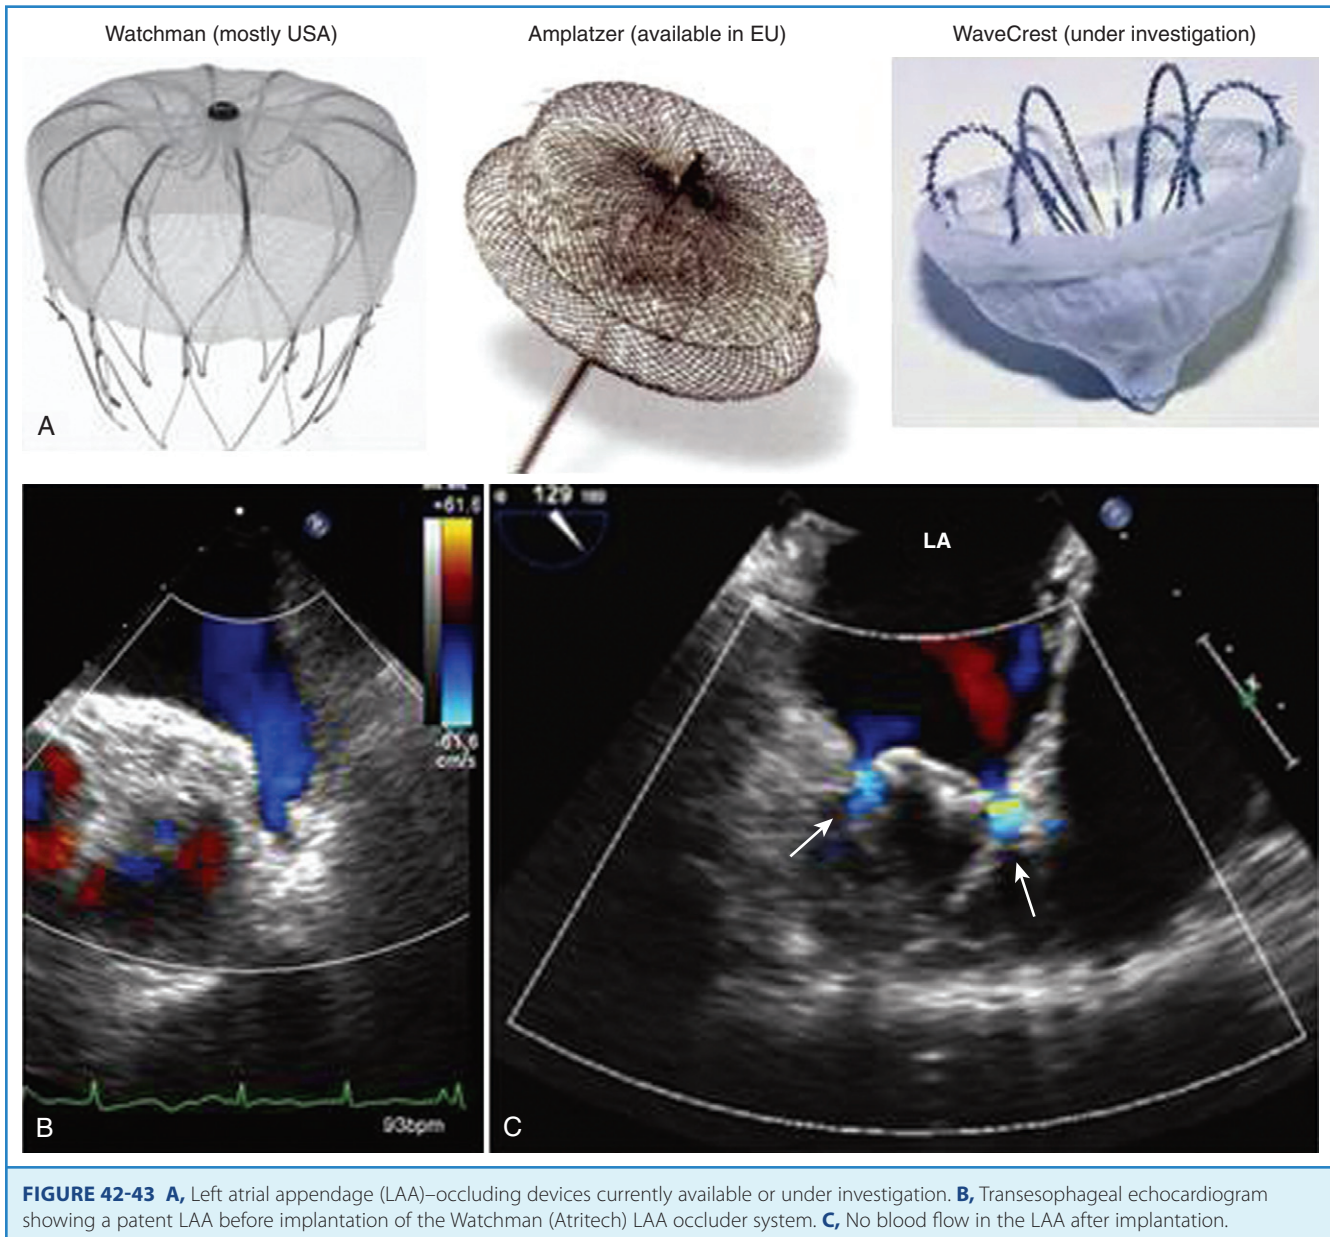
A, Left atrial appendage (LAA)-occluding devices currently available or under investigation. B, Transesophageal echocardiogram showing a patent LAA before implantation of the Watchman (Atritech) LAA occluder system. C, No blood flow in the LAA after implantation.
